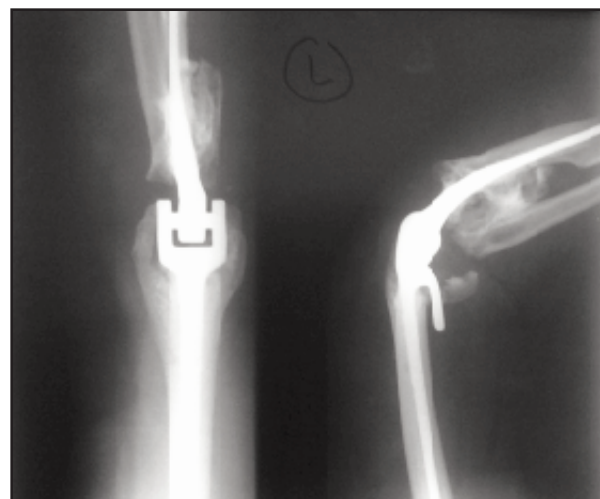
Post operative radiograph of the patient showing the semi constrained total elbow arthroplasty .
